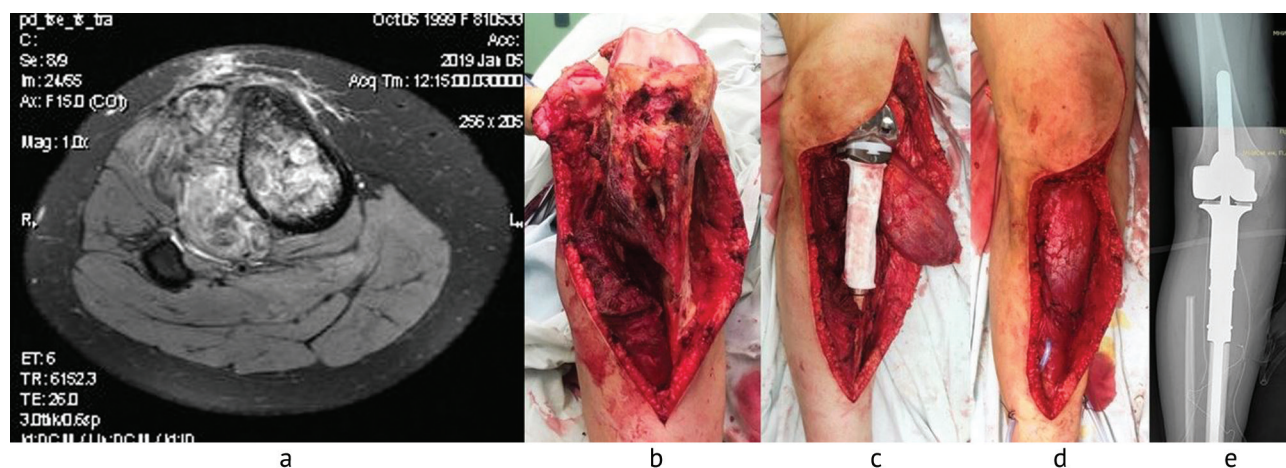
MRI of chondrosarcoma in the proximal tibia (a) ; tumour mobilized from surrounding soft tissues (b); knee endoprosthesis with a mobilized portion of the calf muscle (c); bed for endoprosthesis (d); radiograph after surgery (e)
